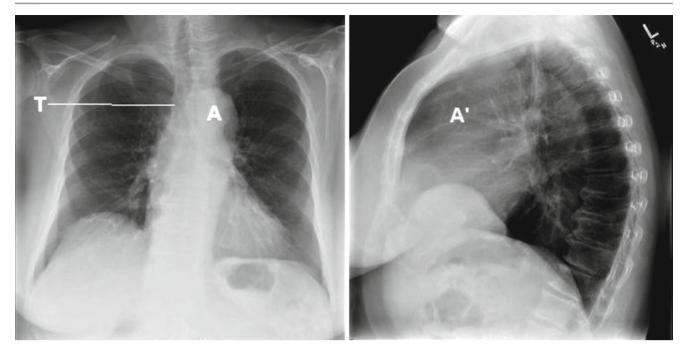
A chest roentgenogram with posteroanterior and lateral views (*left* and *right panels*, respectively), showing a 5.7-cm ascending aorta in both the posteroanterior film (A) and the lateral film (A). Though the aortic knob is enlarged when examined in posteroanterior
